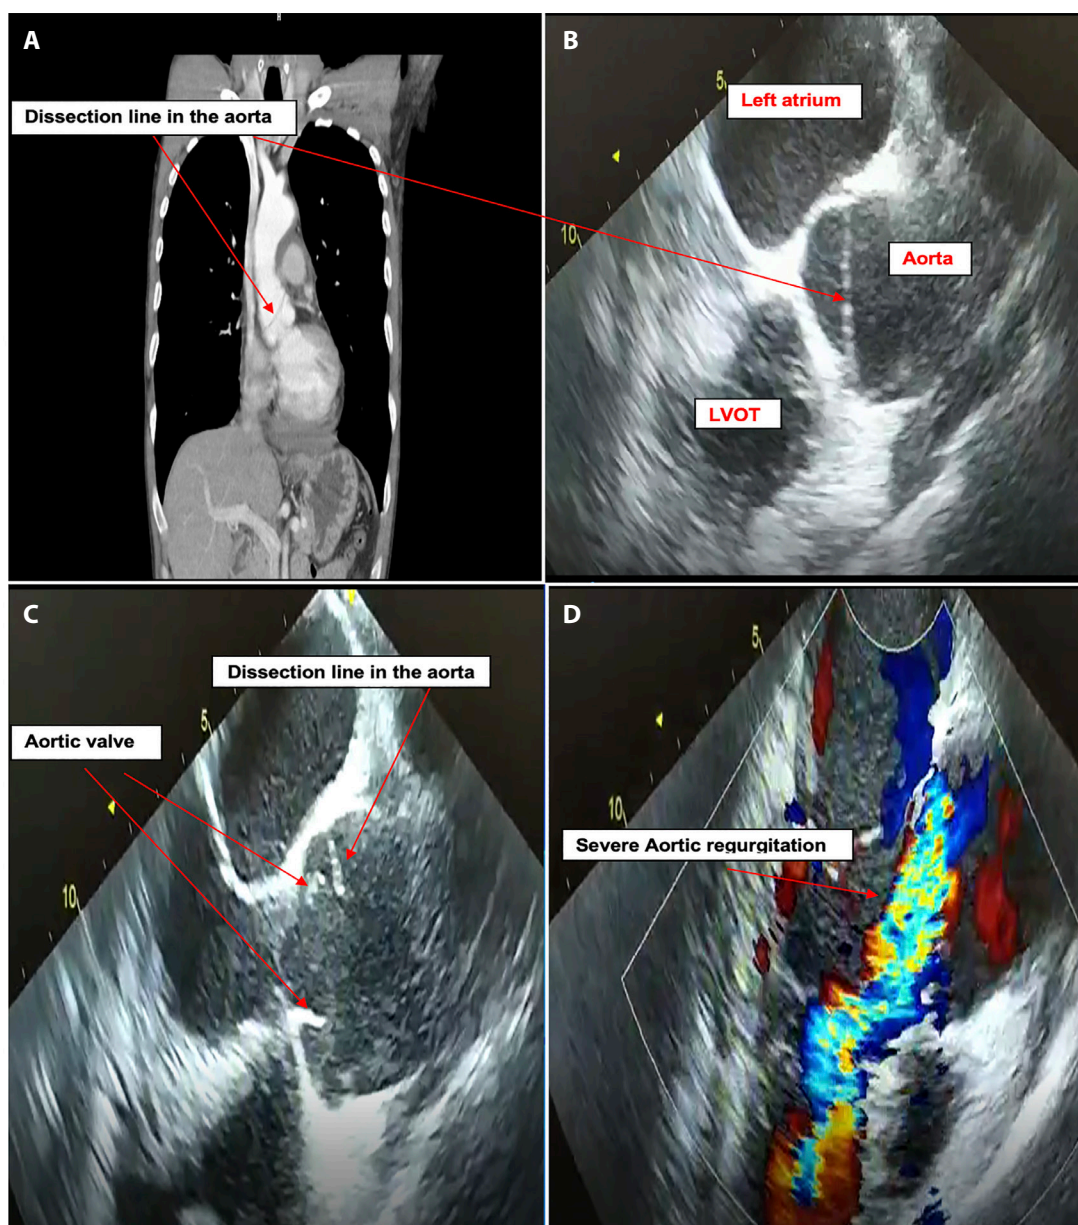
A; Dissection line is seen on tomography. B- C; Transesophageal echocardiography shows a dissection line. D; Transesophageal echocardiography shows severe aortic regurgitation.
